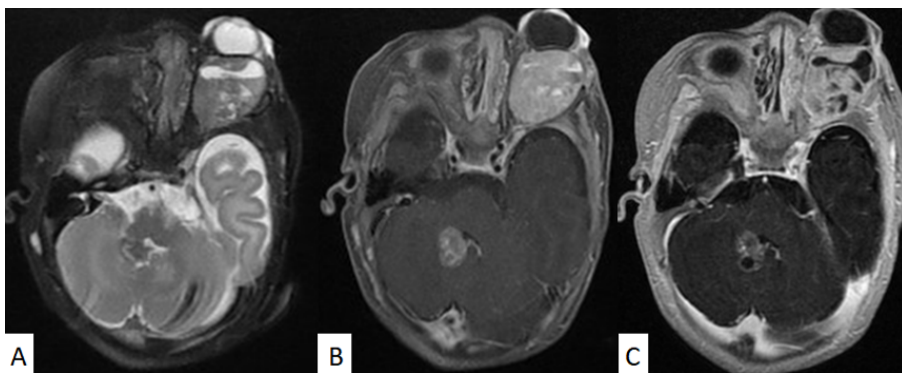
Magnetic Resonance Imaging of the orbit at admission: Axial T2 (A) Axial T1 FAT SAT (B) Gadolinium injection (C)
